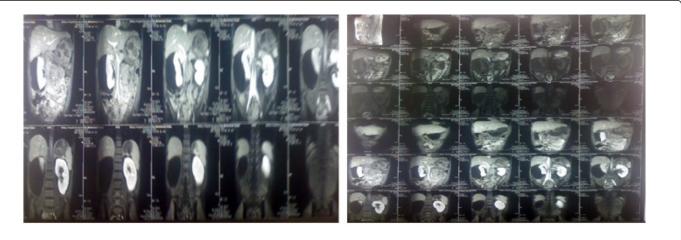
MRI abdomen with section pointing renal collection (t1ws and t2ws).
